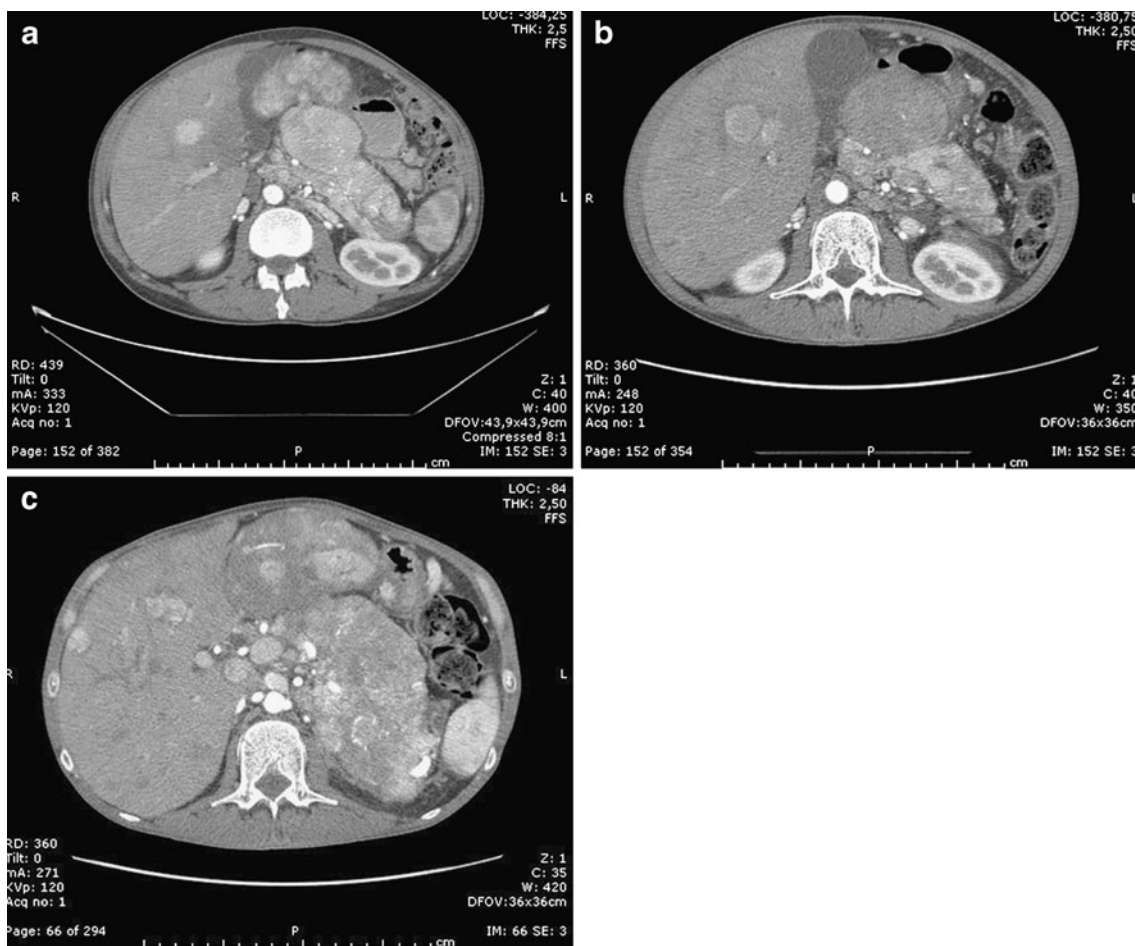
Abdominal CT scans of the 11-cm-long solid lesion in the pancreas, taken a before treatment; b after 3 months on sorafenib therapy, revealing a reduction of arterial enhancement; and c after 6 months on therapy, showing a slight reappearance of arterial enhancement
